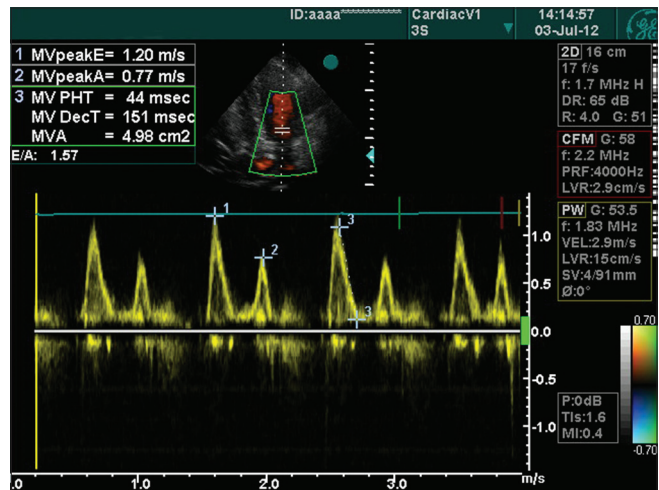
Severe diastolic dysfunction in mitral valve (Doppler)
